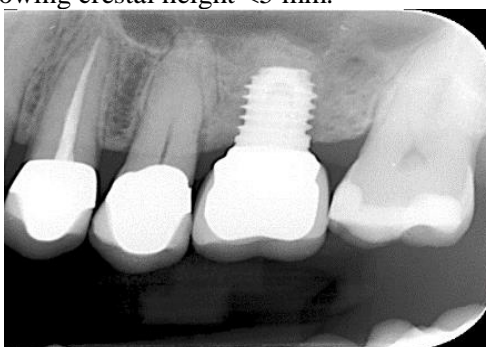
At crown delivery, radiographic findings suggested ongoing consolidation and maturation of the area grafted with calcium-phosphosilicate injectable bone substitute.
